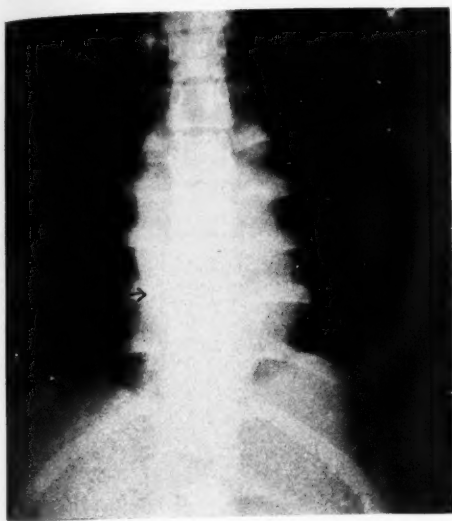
An antero-posterior roentgenogram of the spine in Case 1. The typical, irregular, bilateral, fusiform-shaped abscess shadow is outlined by the arrows. Note the normal appearing vertebrae.
